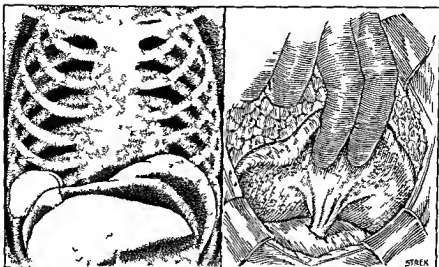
Intrathoracic lobe of liver This mass of normal liver was discovered upon a roentgenogram of the chest Whether this represents congenital lobulation of the liver or extrusion of normal liver into the chest through a diaphragmatic defect was not determined In any event its hepatic origin was betrayed preoperatively by a roentgenogram taken after introducing air into the peritoneal cavity (Left) This mass was easily removed and the diaphragmatic defect closed (Right) (Redrawn by permission after E T Hansbrough and R J Lipin *Annals of Surgery* 145:564 1957)
